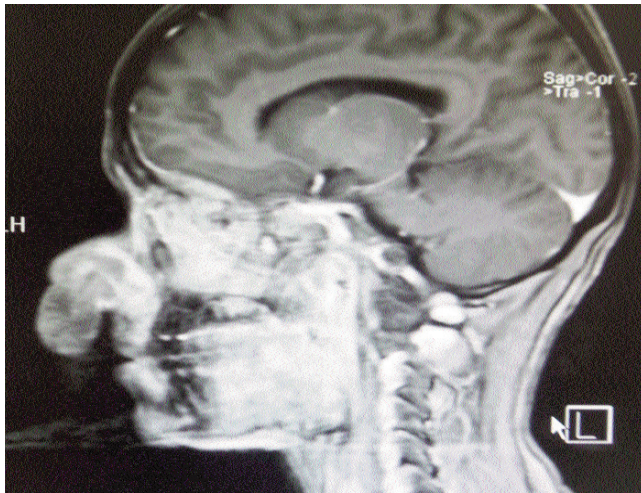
Sagittal MRI of the patient showing a large exophytic mass in the right nasal cavity, bulging posteriorly and almost completely obliterating the nasopharyngeal lumen.
